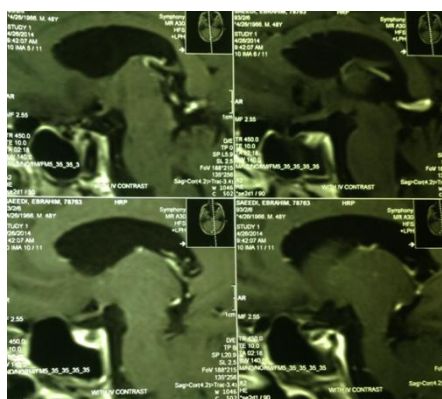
Brain MRI of pituitary gland after six months of target therapy
